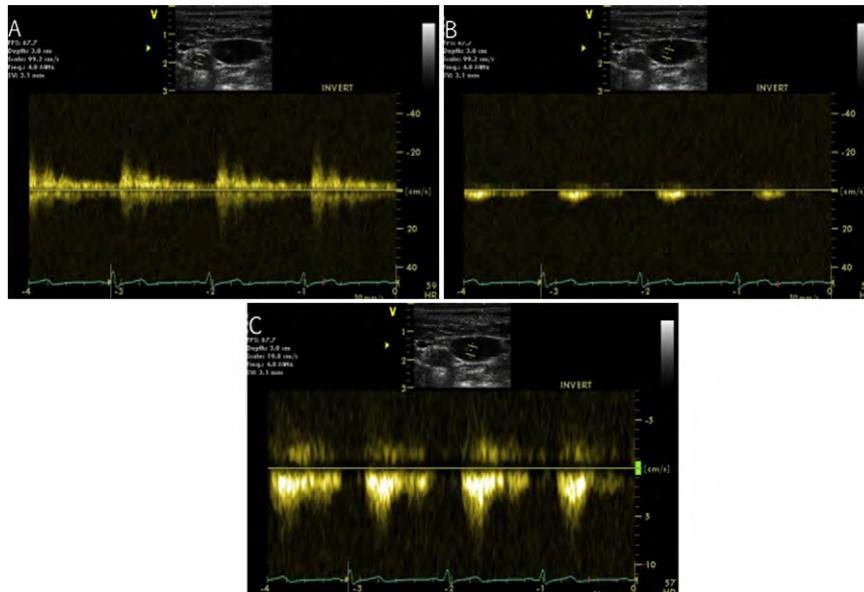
Vessel identification with pulsed-wave Doppler will distinguish artery (A) from vein (B) at a Nyquist limit of ± 50 cm/sec. Arterial blood flow has a predominately systolic component and higher velocity (A) compared with venous blood flow (B,C), which has systolic and diastolic components and much lower velocity, better delineated with a lower Nyquist scale (± 9 cm/sec) (C).
